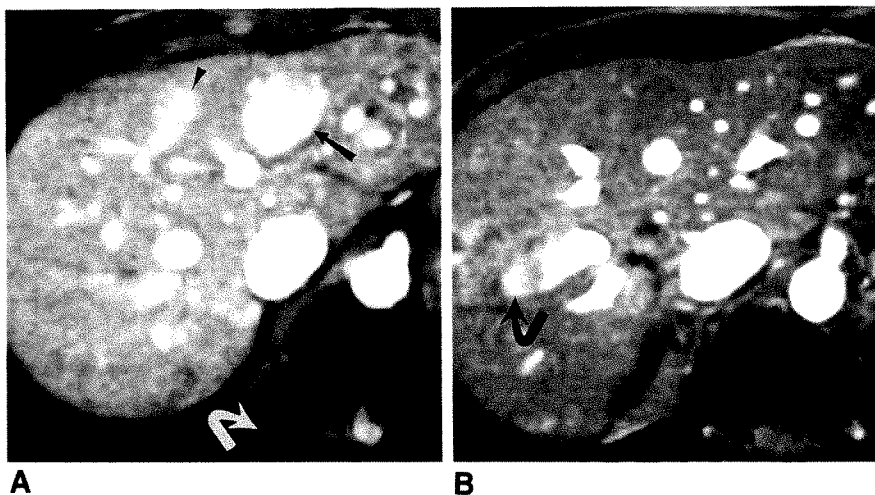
A, Fast imaging with steady-state precession (FISP), 45°-flip-angle MR image of upper liver. Phase-encoded direction in y-axis. A focal bright pseudolesion (straight arrow) is noted in left lobe. Extremely subtle phase artifact is difficult to see (curved arrow). A smaller pseudolesion that is harder to see is noted (arrow-head) anterior to right hepatic vein.
